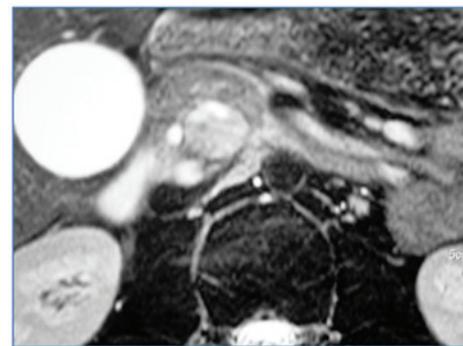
T2-weighted magnetic resonance image. The lesion appears sharply margined with a heterogeneous high-intensity signal.
